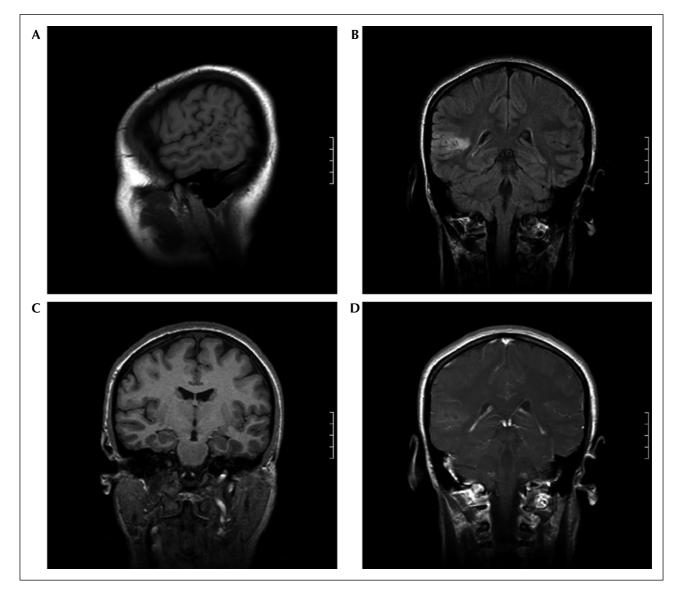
Selected T1 (A, C), FLAIR (B) and gadolinium enhanced (D) MRI brain showing cystic, non-enhancing, heterogeneous lesion at the junction of the right superior and middle temporal gyri.
